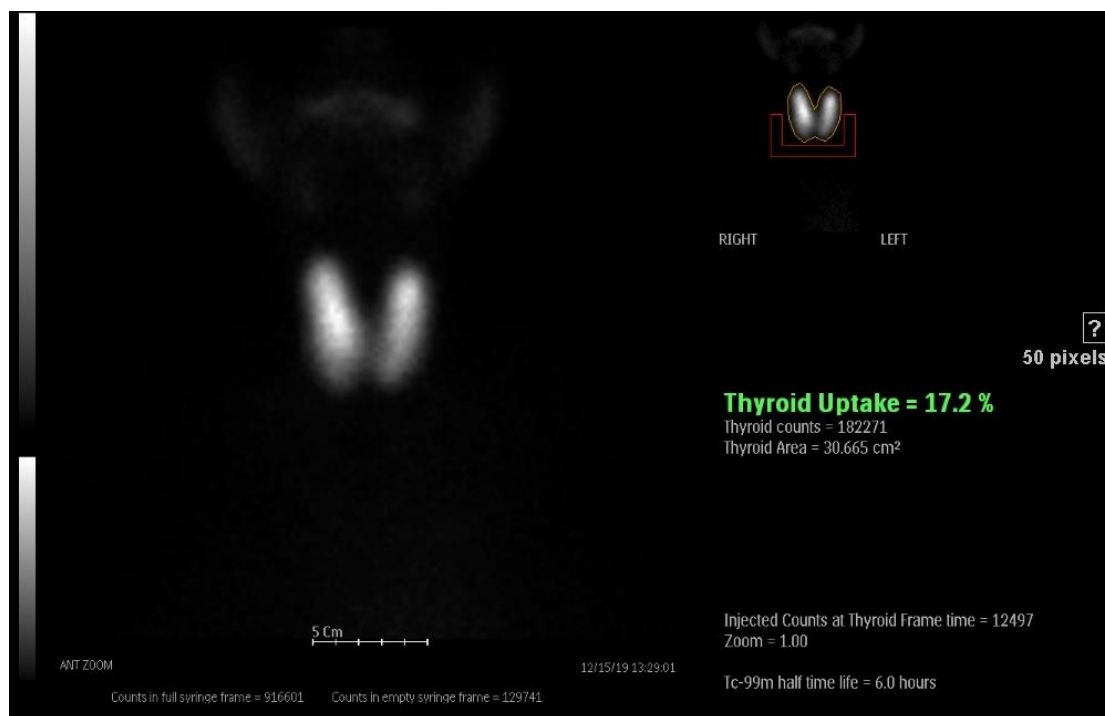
Technetium-99m pertechnetate scintigraphy showed enlargement thyroid gland, with increased homogeneous radiotracer uptake. There is a decrease in background activity. Thyroid uptake value: 17.2 % (normal range between 0.5% to 3.5%). The findings are consistent with Diffuse Toxic Goiter (Graves' disease).
